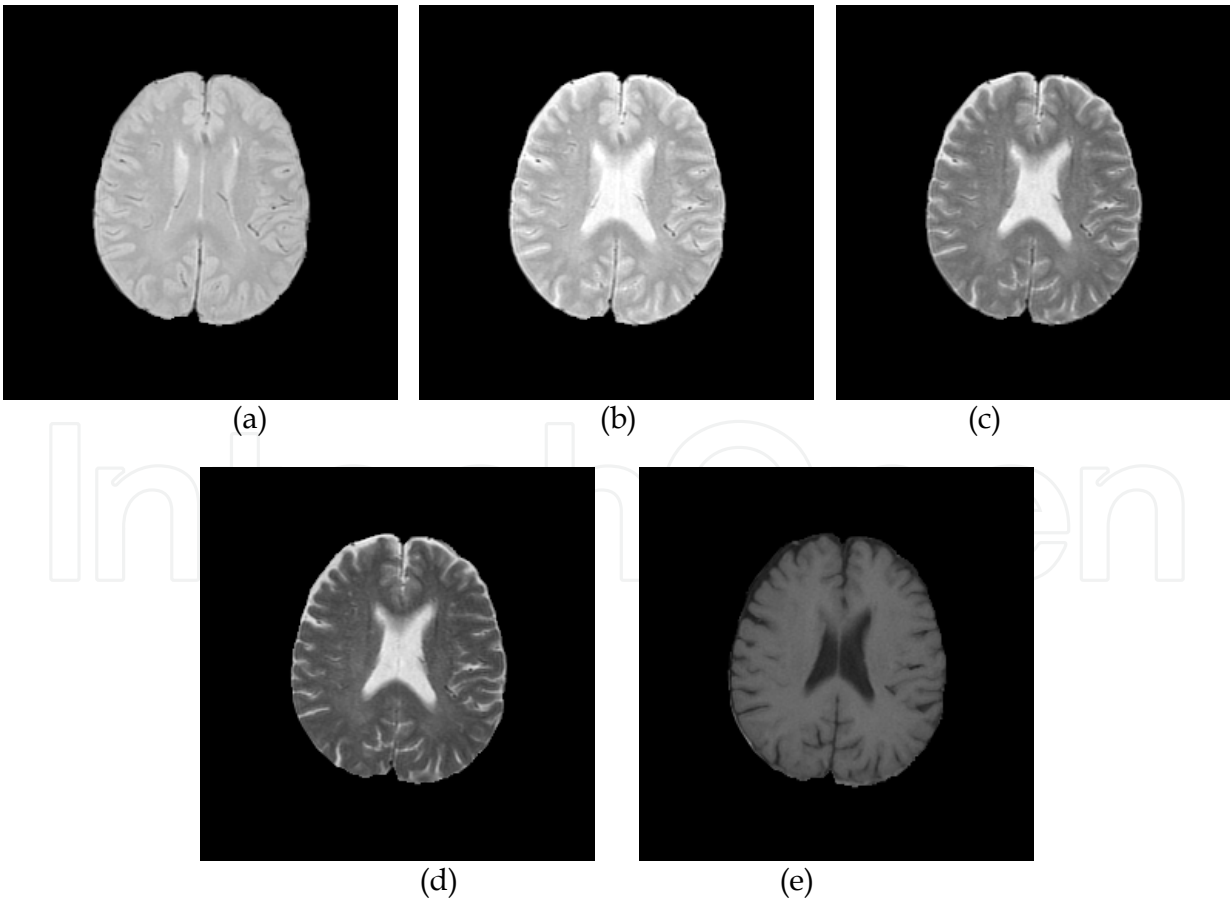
Real brain MR images. (a) TR1/TE1=2500ms/25ms (b) TR2/TE2=2500ms/50ms (c) TR3/TE3=2500ms/75ms (d) TR4/TE4=2500ms/100ms (e) TR5/TE5=500ms/11.9ms
